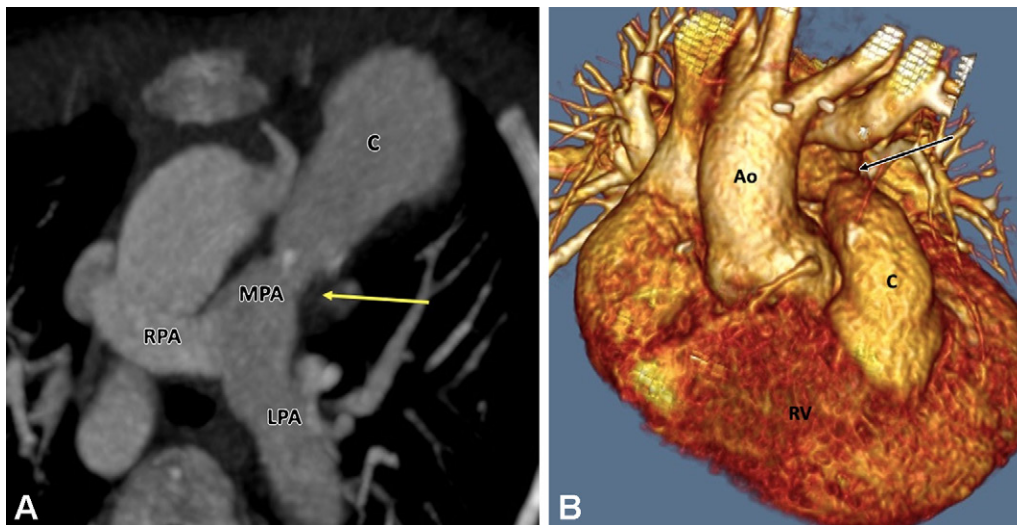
Postoperative appearance of truncus arteriosus after RV-PA conduit formation and VSD closure in a 13-year-old boy. (A) Axial maximum intensity projection CT image shows mild stenosis in the MPA at the anastomotic site of the conduit (yellow arrow). (B) Volume-rendered image confirms these findings. Ao = aorta, C = conduit, LPA = left PA, MPA = main PA, PA = pulmonary artery, RPA = right PA, RV = right ventricle, VSD = ventricular septal defect.
